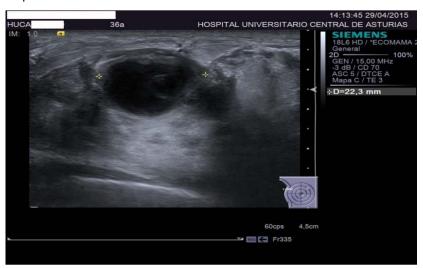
First breast ultrasound showed the presence of heterogeneous hypoechoic structures compatible with abscesses
